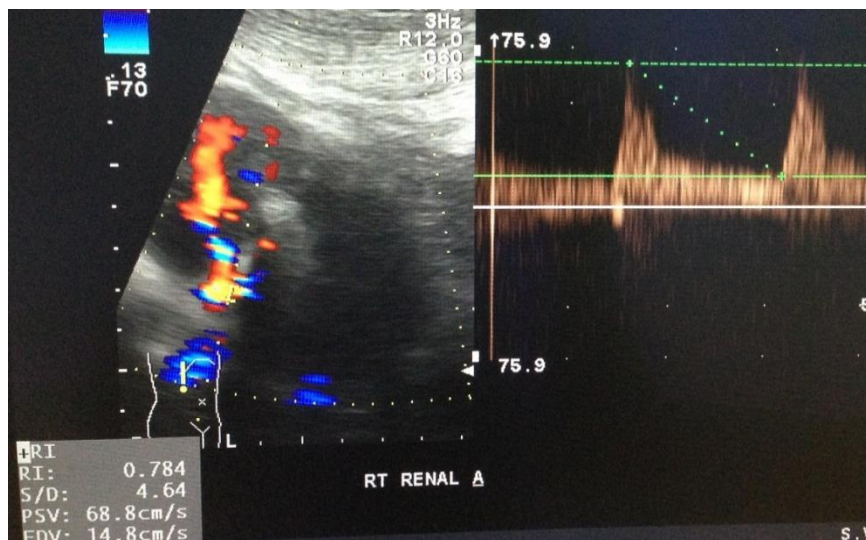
Doppler ultrasound of the right renal artery showing a preserved waveform pattern but the RI is raised.(normal RI <math><0.7</math>)
